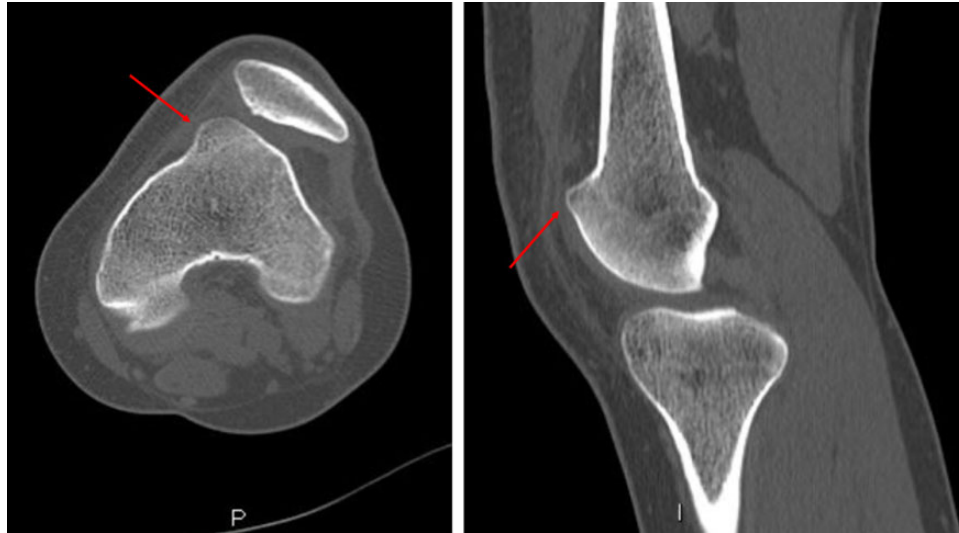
Preoperative computed tomography images for a 19-year-old woman with Dejour type D trochlear dysplasia. This patient has a supratrochlear spur (arrows) measuring 9 mm with lateral patellar dislocation, which is an indication for sulcus-deepening trochleoplasty with medial patellofemoral ligament reconstruction.
